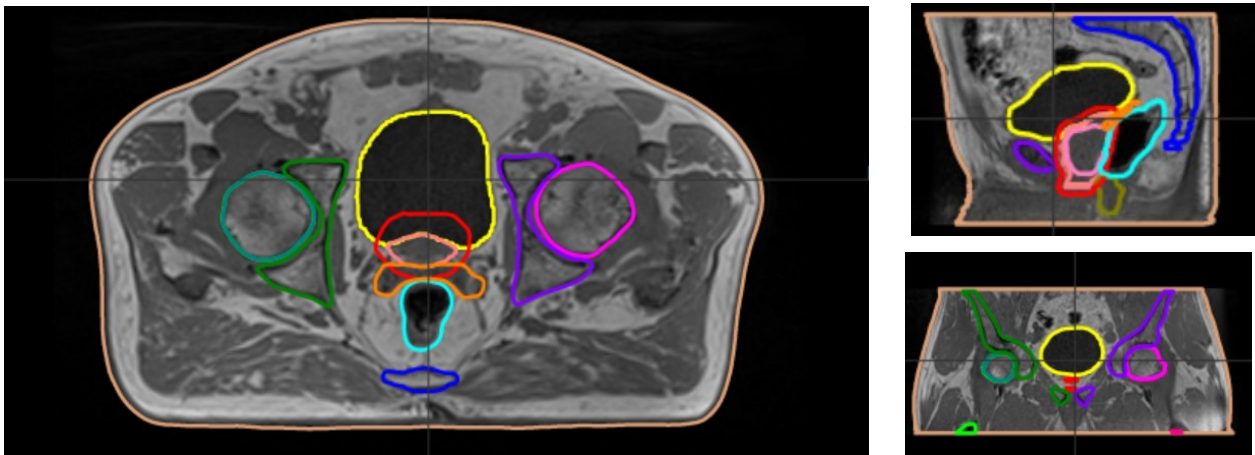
Example of MR images automatically contoured by Admire software.
